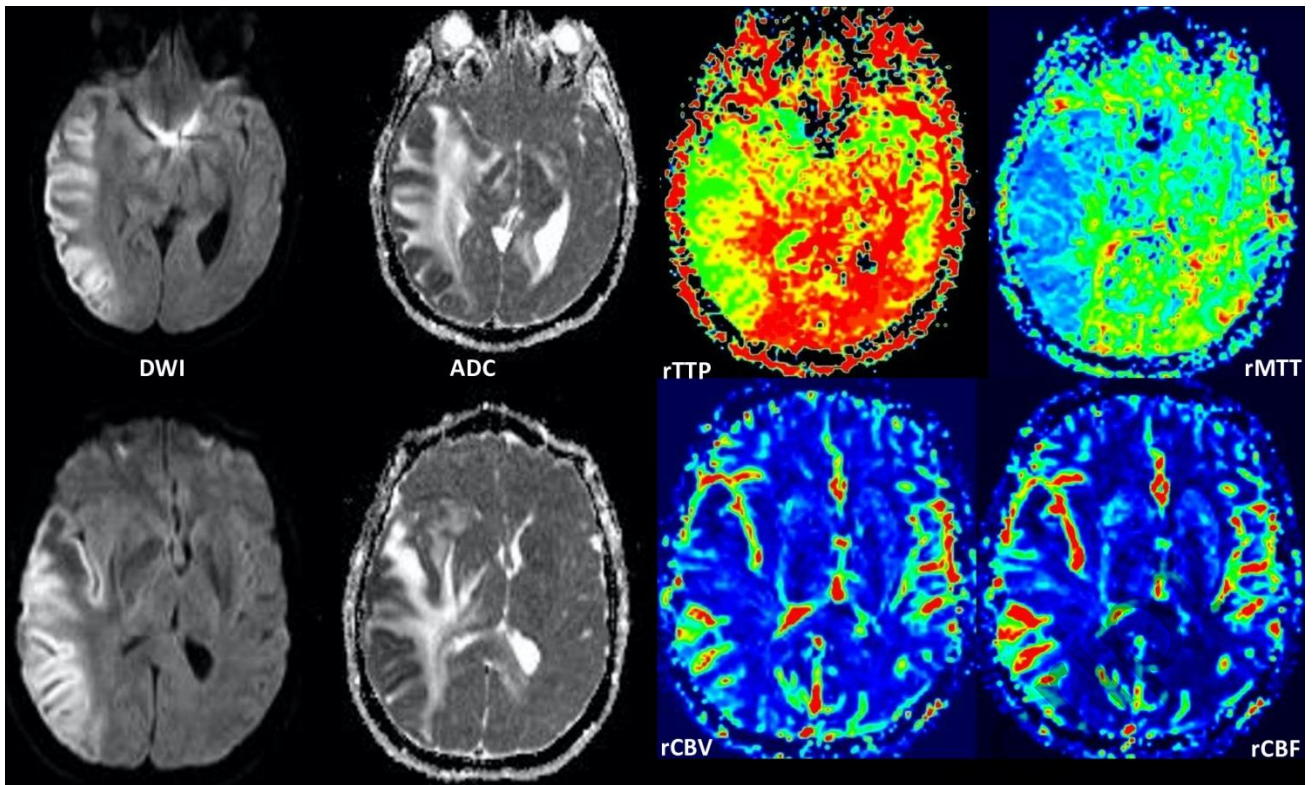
Head MRI, DWI and Perfusion Study, axial view: diffusion weighted imaging (on the left) shows extensive cortical marked restriction of the interested regions in right emisphere without images of hyperperfusion on qualitative parametric maps (on the right).
